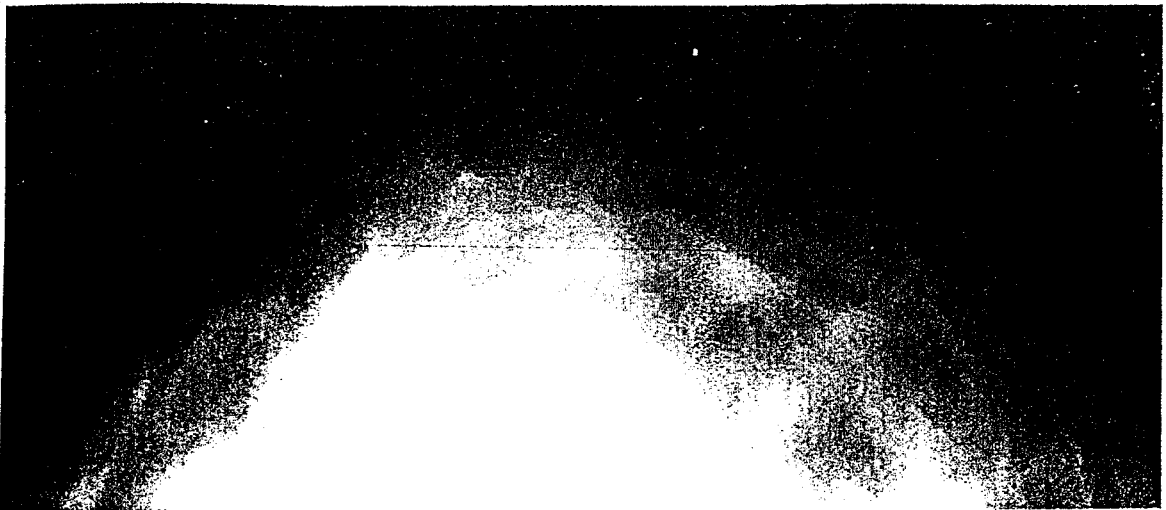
(a) Left breast, x-ray image.
